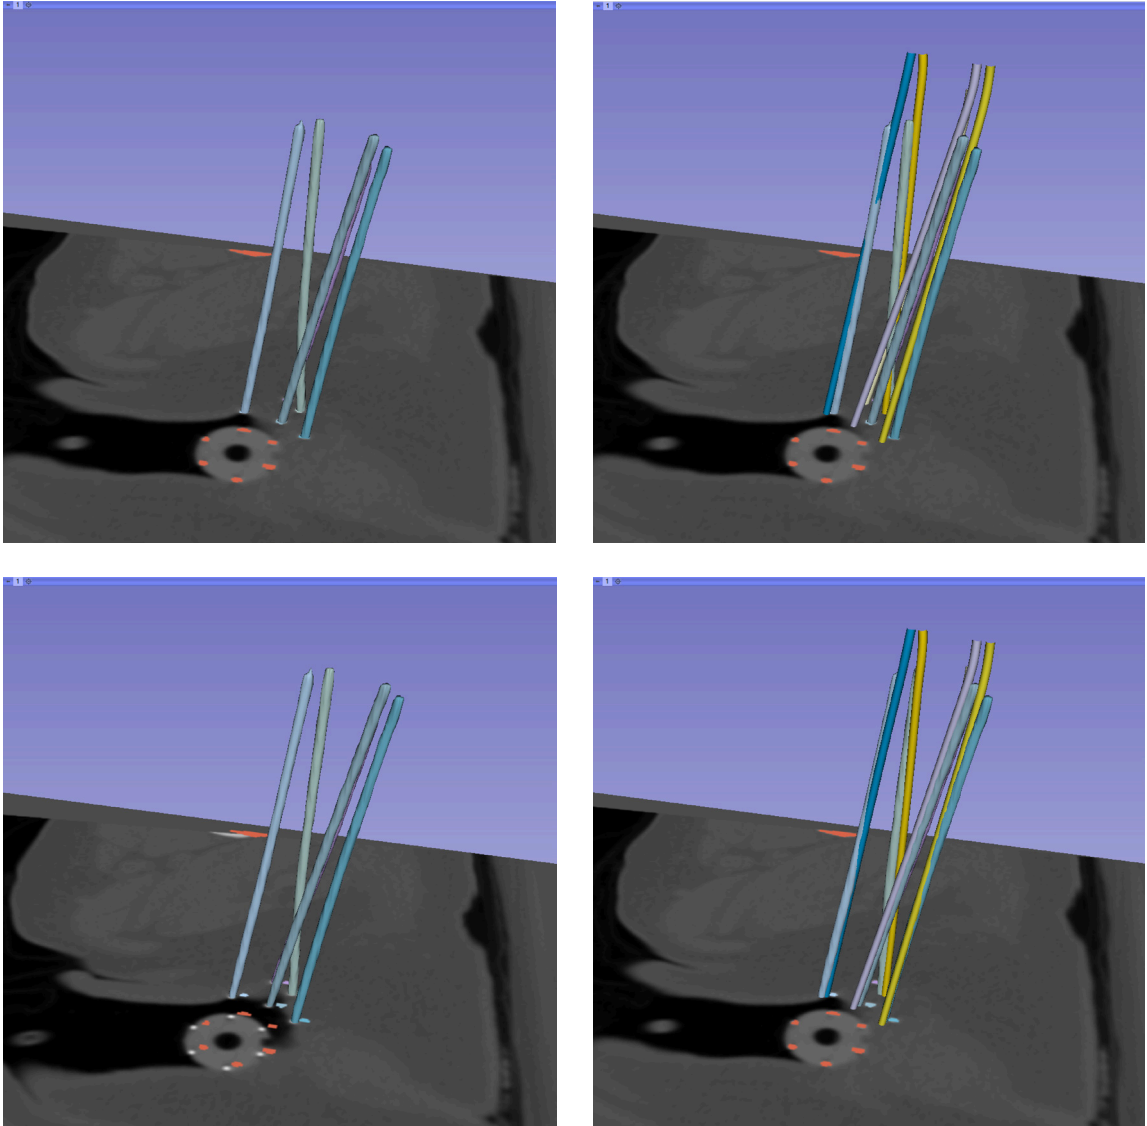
The first column presents the models of the needle extracted by thresholding in the CT images for the case 6 and the second column shows an overlay of those mentioned models on models of algorithmically segmented in MR images. The first shows the results prior to the Iterative Closest Point registration between point clouds of CT needles and MR needles; the second row shows the result after the ICP registration
